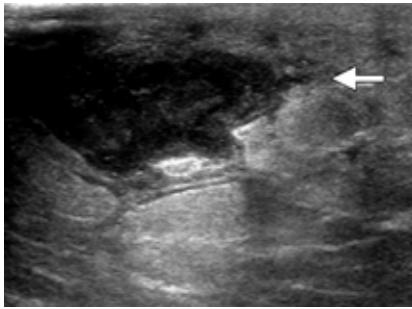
Breast abscess appearing as a hypoechoic area on ultrasound with ill-defined margins; needle aspiration obtained pus from this area, which helped diminish bacterial load and also provided a sample for bacterial culture and sensitivity studies
